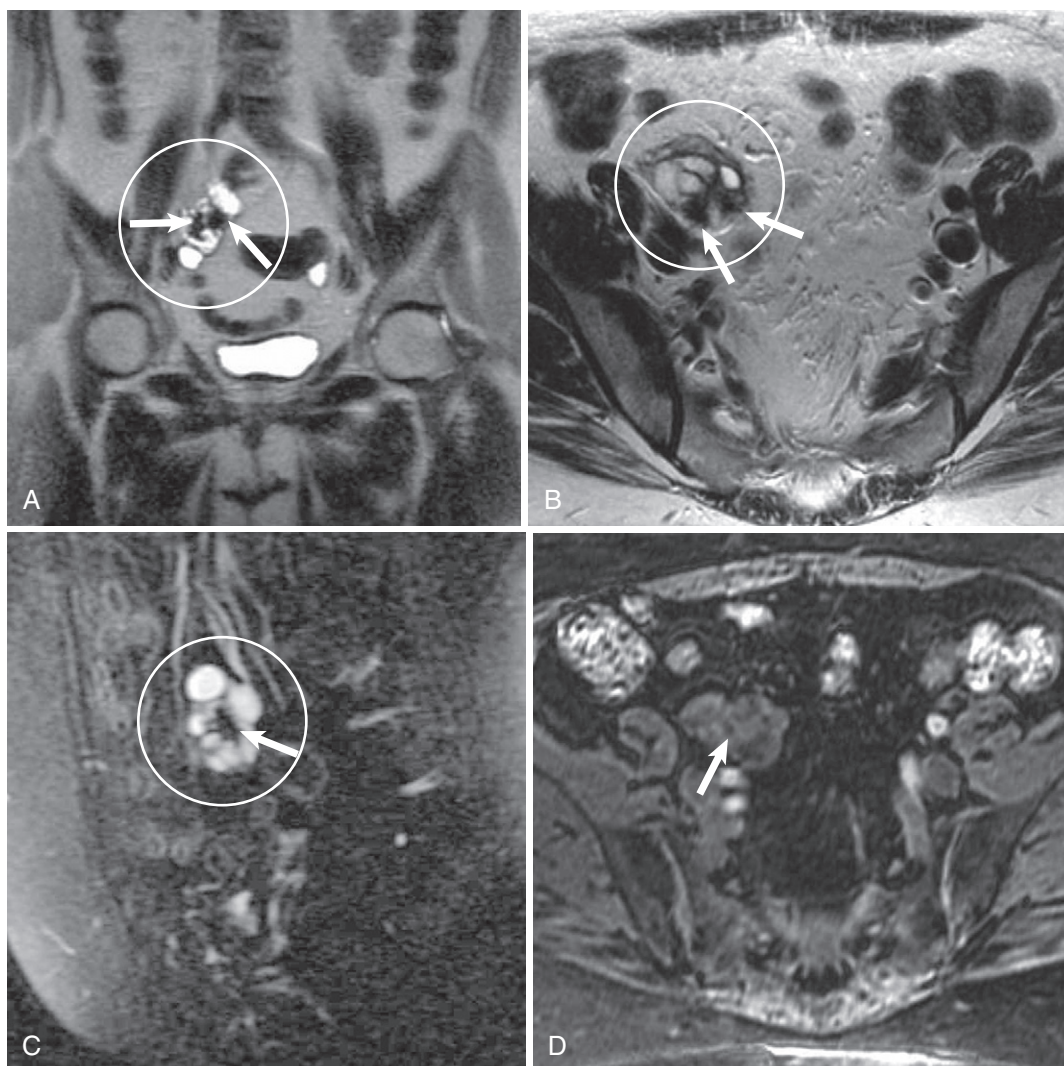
Cystadenofibroma. Coronal (A) and axial (B) T2-weighted and sagittal fat-suppressed (C) images of a right ovarian cystadenofibroma (*circle*) show at least two dark clumps of fibrous tissue (*arrows*). D, There is mild enhancement of the septa and fibrous plaque (*arrow*).
